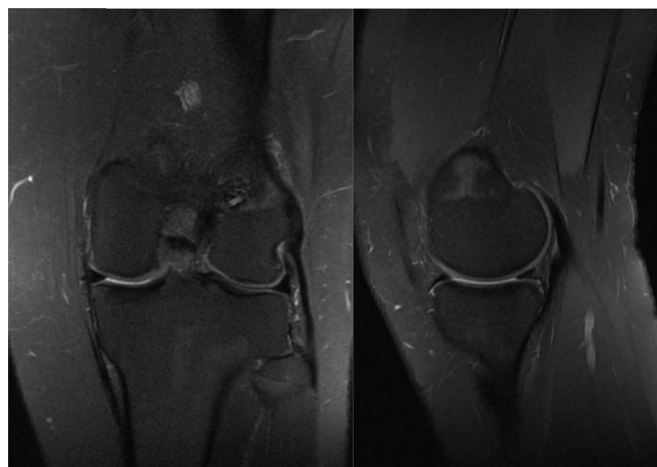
MRI of a patient, 2 years after repair in the body and posterior horn of the lateral meniscus (grade 3 lesion).
